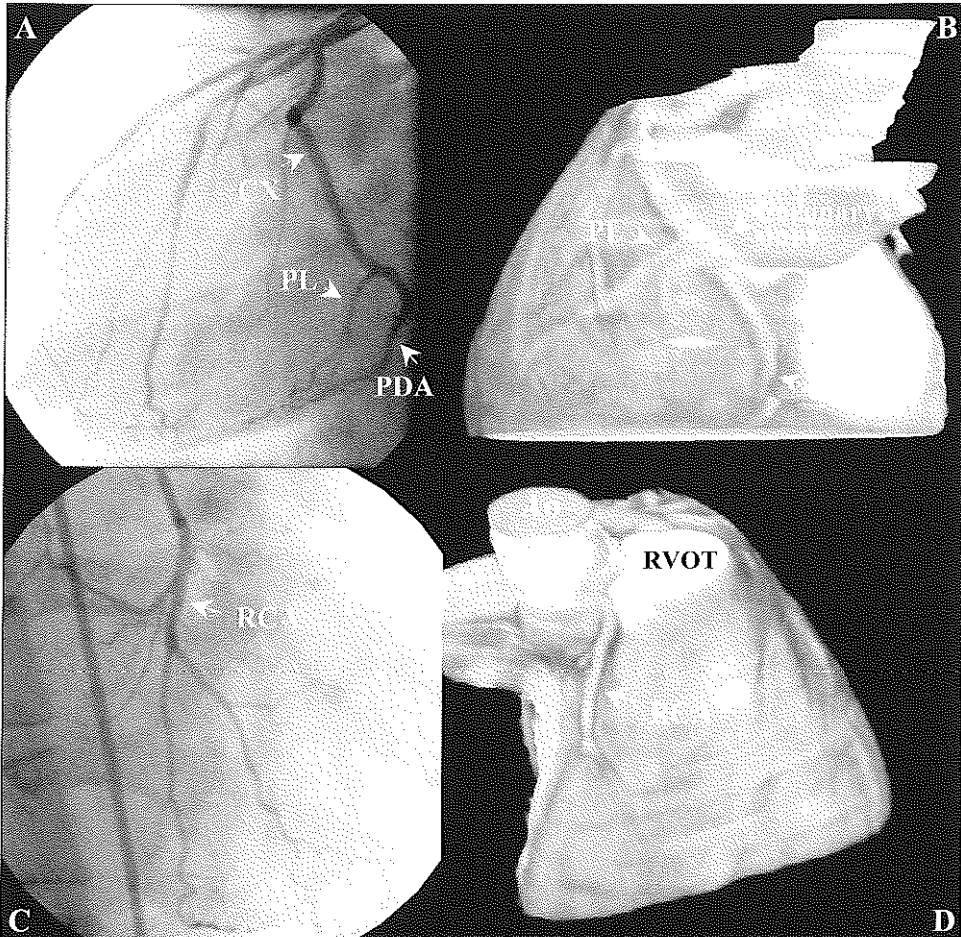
Left coronary artery dominance. Posterior descending artery (PDA) and postero-lateral (PL) branch originate from the circumflex (CX) coronary artery. In (A) and (C) the images are obtained by conventional coronary angiography. (B) Magnetic resonance imaging, left posterior view. Coronary sinus covers CX artery. (D) Magnetic resonance imaging, right anterior view. In left coronary artery dominance there is only a small right coronary artery (RCA). Technique same as in Figure 1. Ao, Aorta; RVOT, right ventricular outflow track.
